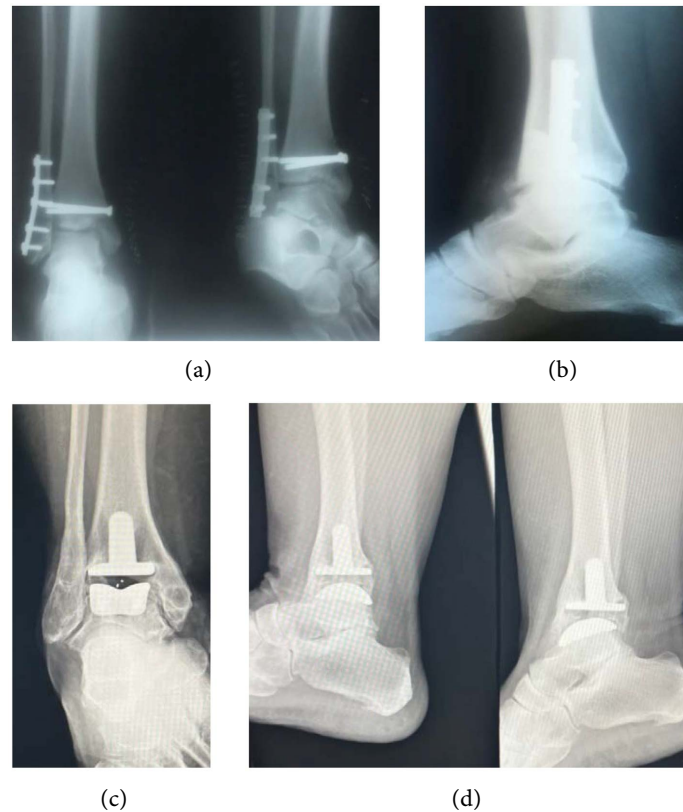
Pre-operative and Post-operative X-rays of a 42 year old female patient with Post-traumatic arthritis of the Right Ankle and Retained Hardware. (a) Pre-Operative, Anterior-posterior (AP) X-rays; (b) Pre-Operative Lateral, X-ray of the same patient; (c) Post Operative, A/P X-ray of the same patient in A & B, Metals: 24 Years, Bearing: 15 Years; (d) Post-Operative Lateral, X-rays of the same patient in A & B, Metals: 24 Years, Bearing: 15 Years.
